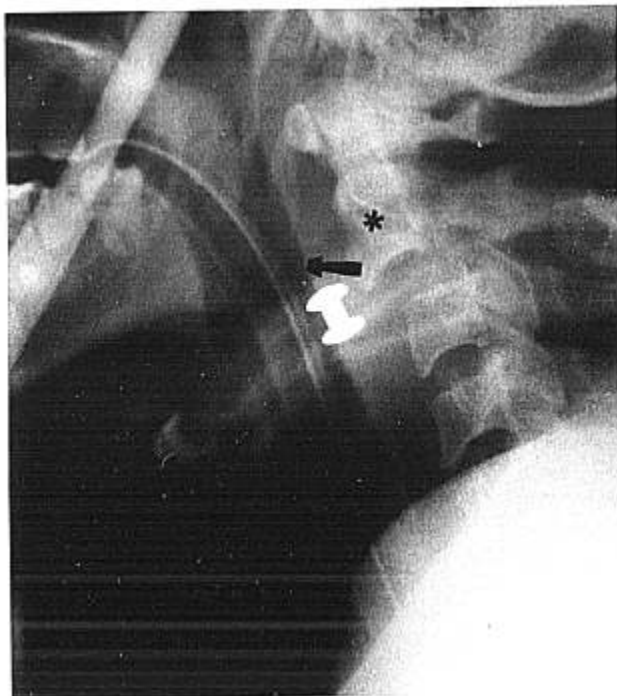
Lateral neck radiograph 7 days after admission shows reduction in PSTS (arrow) to 12 mm anterior to C2 (asterisk), and patent airway between the anterior edge of the PSTS and the posterior edge of the endotracheal tube. Subluxation of C2 on C3 is again seen.
